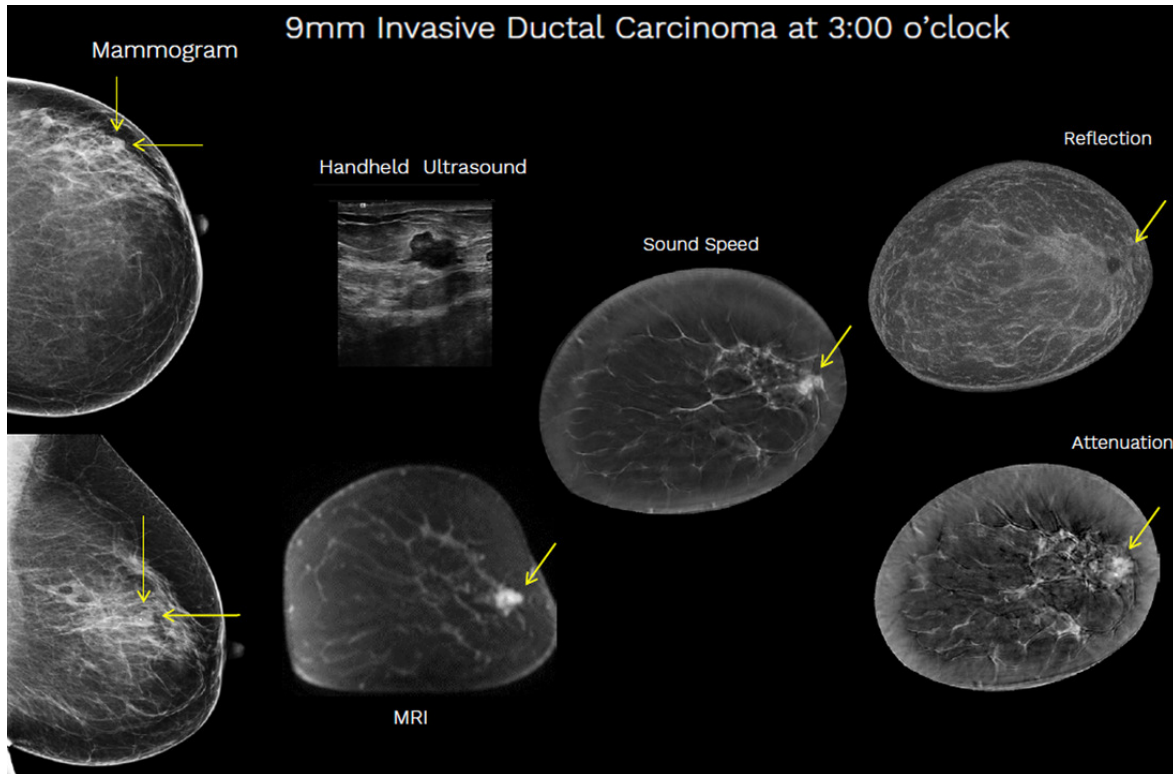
Comparison of breast imaging methods based on the example of a breast suffering from an invasive ductal carcinoma. On the left side mammograms in the transverse (top) and sagittal plane (bottom) are shown. In the middle column the results of handheld B-mode ultrasound and magnetic resonance imaging in the coronal plane are shown. On the right side coronal speed of sound, attenuation and reflectivity reconstruction, obtained by iterative bent-ray tomography and synthetic aperture focusing techniques are presented. Data for the latter were acquired with the SoftVue ultrasound tomography system (Delphinus Medical Technologies, 2018).
